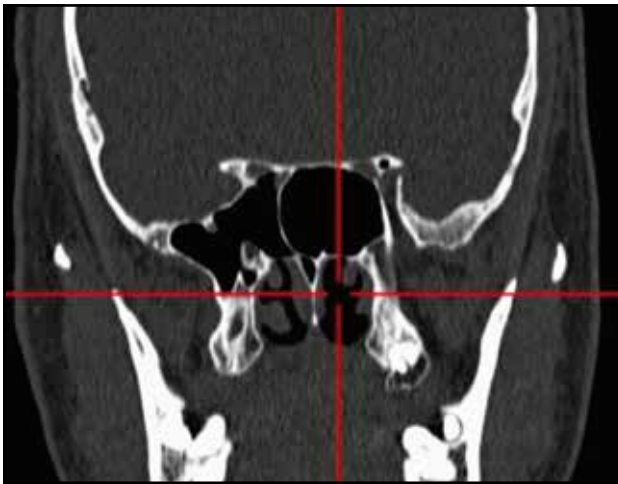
Complete lateral extension- pneumatization which extends in the greater wing and in the pterygoidian process (cranio-facial CT scan, coronal slice).
